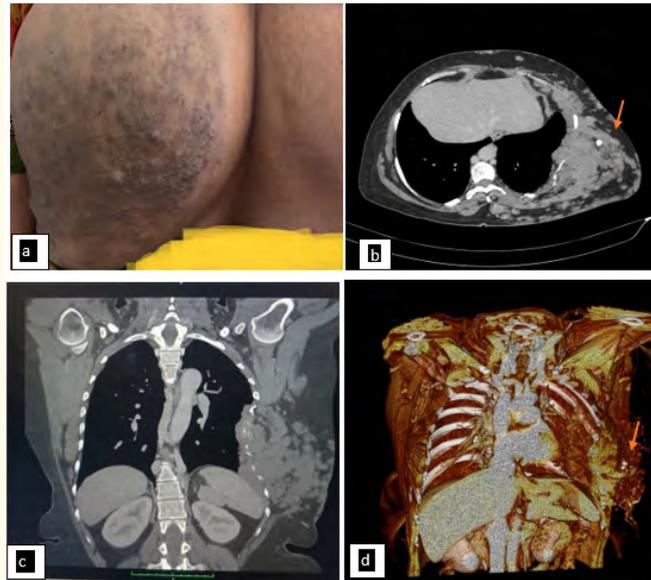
(a) Photograph showing lesions at back (b), (c) and (d) Axial, coronal and volume rendered contrast enhanced CT images of thorax shows an ill-defined enhancing left thoracic wall soft tissue attenuating lesion with phleboliths (arrow) and intra thoracic extension causing remodelling and erosions of the underlying ribs. No feeding arteries identified.
